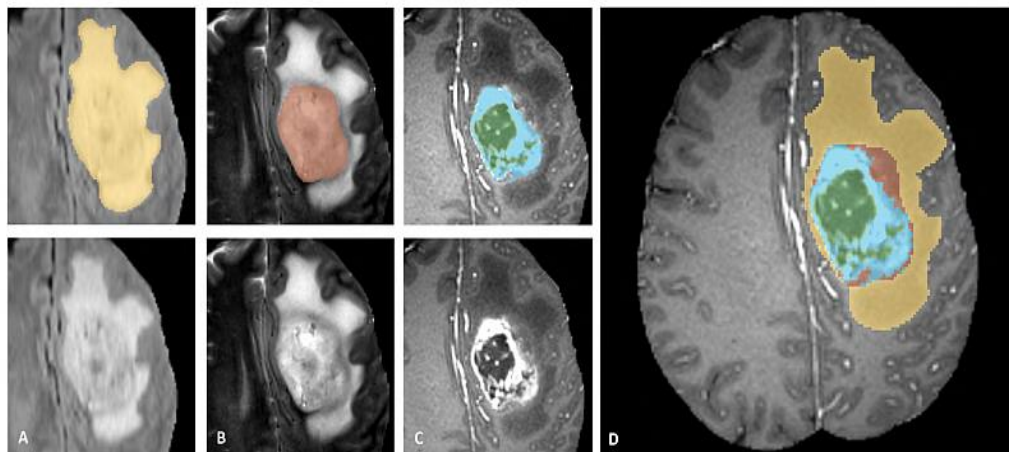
Image panels with the tumor sub-regions annotated in the different MRI scans
